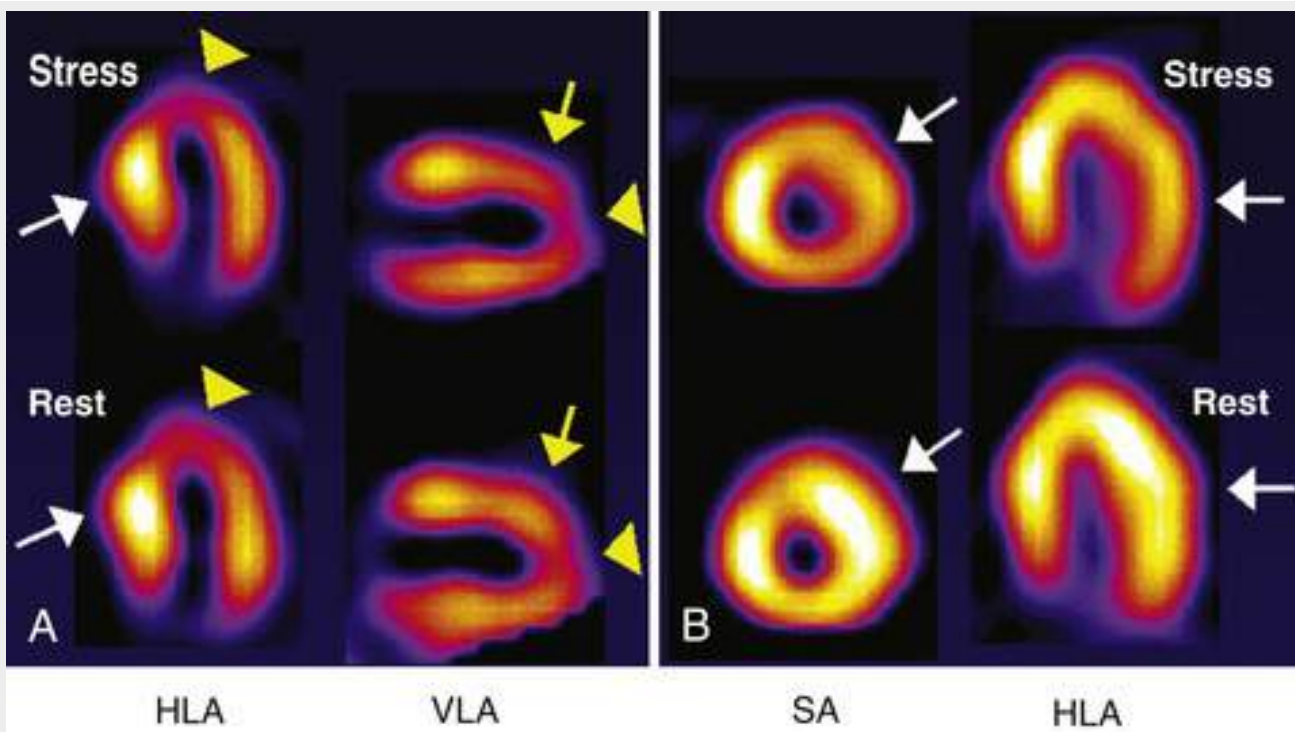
SPECT perfusion imaging in hypertrophic cardiomyopathy in young asymptomatic patients with normal coronary arteries. A, Fixed perfusion defect of the apex consistent with infarction, indicated by *yellow arrowheads* in the horizontal (HLA) and vertical (VLA) long-axis images, with a reversible defect of the anterior wall (*yellow arrows* in VLA images). The hypertrophied septum is evident (*white arrows* in HLA images). B, Extensive inducible silent ischemia in the anterior, lateral, and inferior walls (*white arrows*). Transient ischemic cavity dilation also is present, possibly related to subendocardial ischemia. (Based on data from O’Gara PT, Bonow RO, Maron BJ, et al. Myocardial perfusion abnormalities in patients with hypertrophic cardiomyopathy: assessment with thallium-201 emission computed tomography. *Circulation* 1987;76:1214; and Udelson JE, Bonow RO, O’Gara PT, et al. Verapamil prevents silent myocardial perfusion abnormalities during exercise in asymptomatic patients with hypertrophic cardiomyopathy. *Circulation* 1989;79:1052.)
